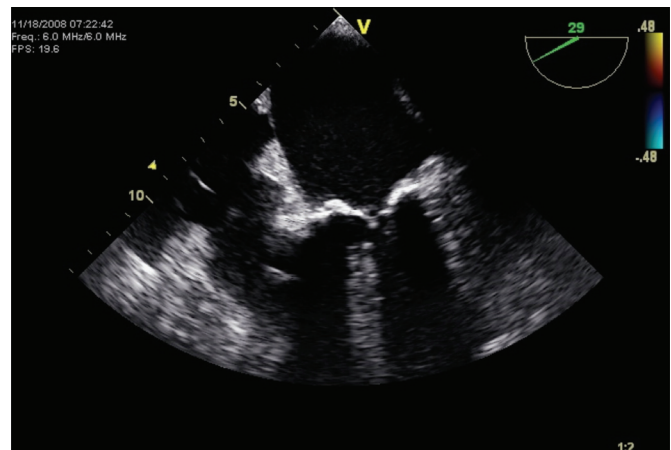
Intraoperative transesophageal echocardiogram without and with color Doppler, showing severe mitral annulus calcification along with severe mitral regurgitation.
